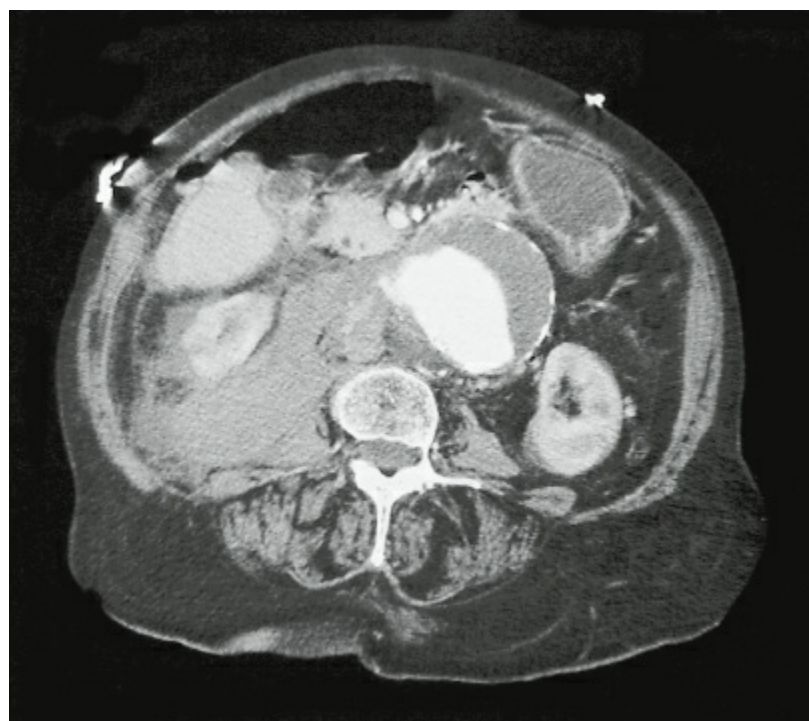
Computed tomography scan of a ruptured thoracoabdominal aortic aneurysm. Note stranding in the retroperitoneum denoting extravasation of blood.
